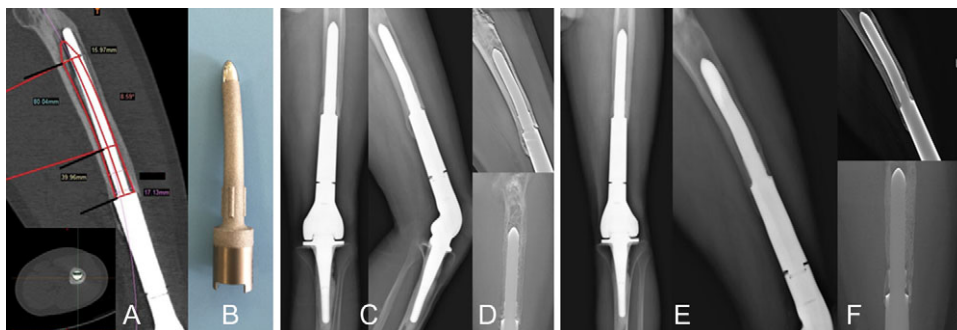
The prosthesis design and the postoperative radiographs of Patient 1 during the revision surgery. (A) the 3D precise design of the prosthesis based on the Mimics 3D images; (B) the prosthesis with titanium coating; (C) the postoperative anteroposterior and lateral radiographs images immediately after the revision surgery; (D) the T-SMART images immediately after the revision surgery; (E) the anteroposterior and lateral radiographs at 1 year follow-up; (F) the T-SMART images at 1 year follow-up.
